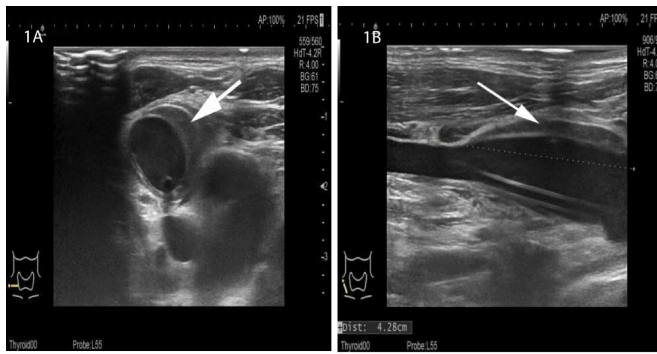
Ultrasound after catheterization (A: Sagittal plane, B:coronal plane):from the center of the middle of the right internal jugular vein to the wall of the root of the neck wall thickening, low echo, low echo can be seen in a membrane-like high echo (the arrow shows the lesion)
